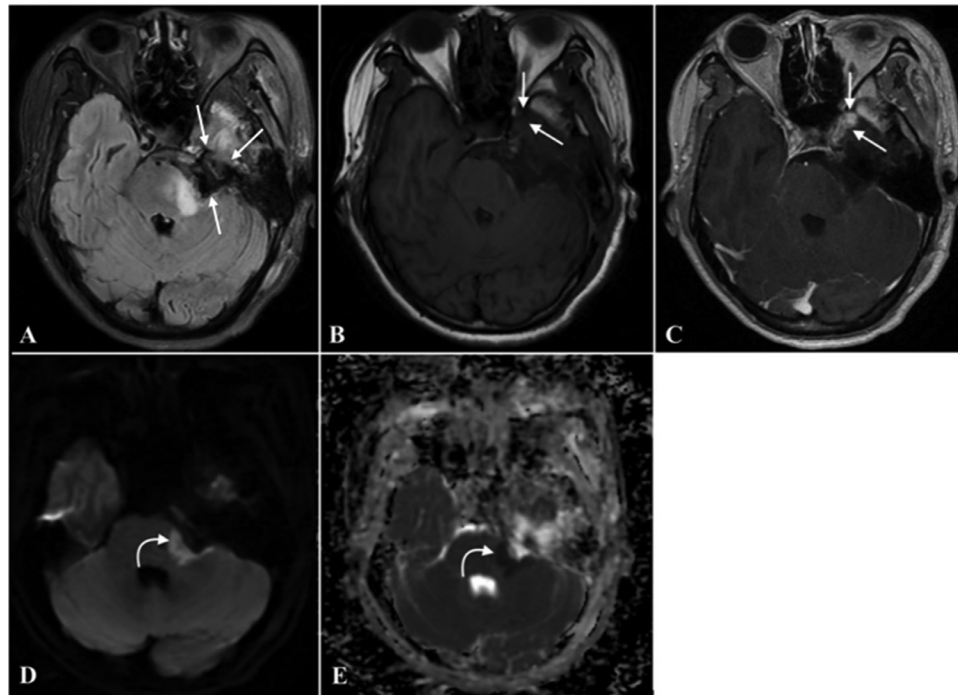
MRI brain images at 4 days postsurgery. (A) An axial fluid-attenuated inversion recovery image shows an enlargement of the subarachnoid space in the left cerebellopontine angle (straight arrows). Comparison of (B) pre- and (C) postcontrast T1W images shows enhancing residual tumor in lateral cavernous sinus wall (straight arrows). (D) An axial DWI with corresponding (E) ADC map shows diffusion restriction in the left middle cerebellar peduncle and pons due to cerebral ischemia adjacent to the tumor bed area (curved arrows).
